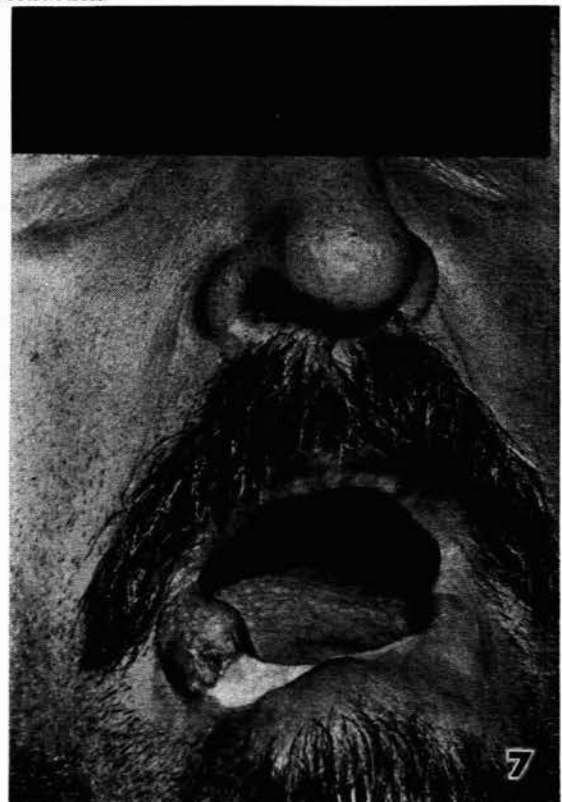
Patient with recurring carcinoma of lower lip after X-ray therapy.
